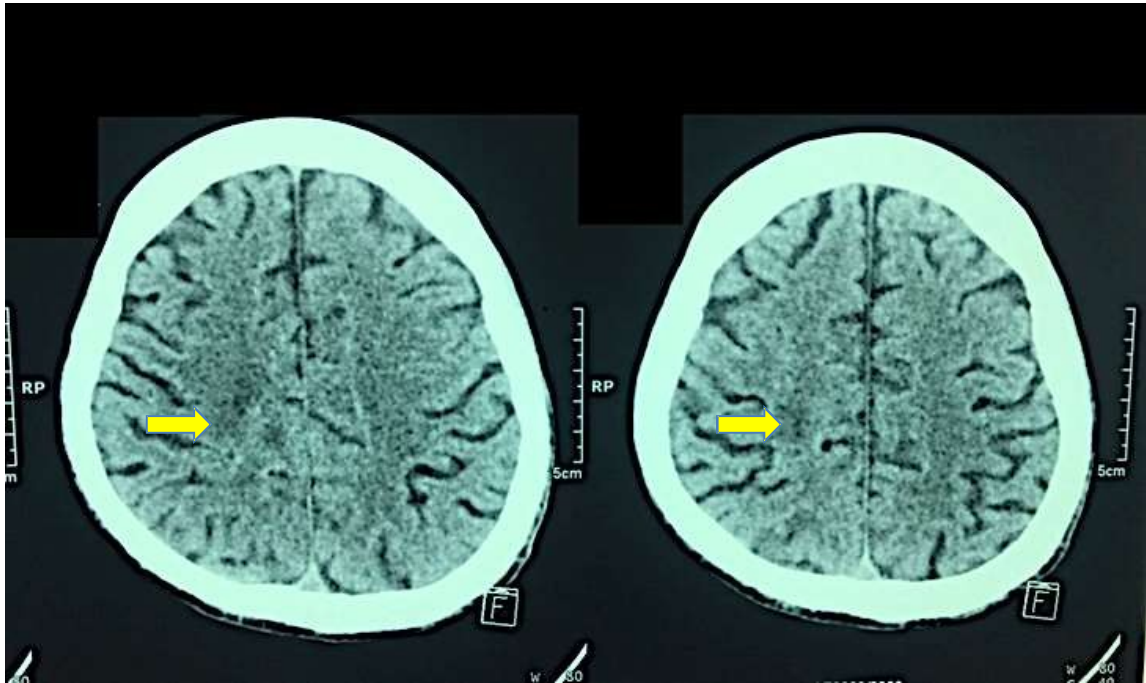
A plain CT-brain of the patient showing the right cerebral hypodensities in the right centrum semiovale, consistent with cerebral abscess (arrow).
